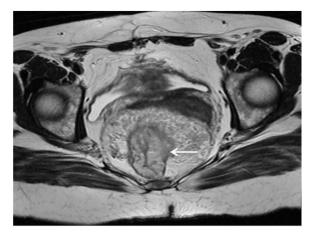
Axial view of the MRI. The arrow is pointing to the thickened rectal wall measuring 16 mm, with important reduction in the lumen and thickening of the mesorectum.
